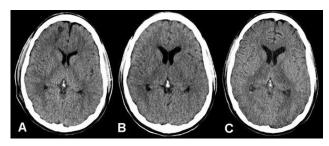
Development of bithalamic edema in cranial computed tomography. (A) On day 5 after trauma, both thalami are of normal density and well delineated against the internal capsule. A hypodense area in the right frontal lobe is a contusional lesion. (B) Because the neurologic status of the patient had deteriorated on day 15 after admission, this computed tomographic scan was performed to rule out septic encephalitis after a febrile episode. There was no sign of inflammatory disease on the contrast-enhanced studies not shown here. With our knowledge of the further progress of the disease, a decrease in density of both thalami and a reduction of contrast between thalami and internal capsule can already be seen in this scan. (C) Because on this computed tomographic scan performed on day 21 both thalami are clearly hypodense, a cerebral sinus thrombosis was suspected. A magnetic resonance imaging study was performed on the same day to differentiate between an edema caused by sinus thrombosis and ischemic cerebral infarction.
